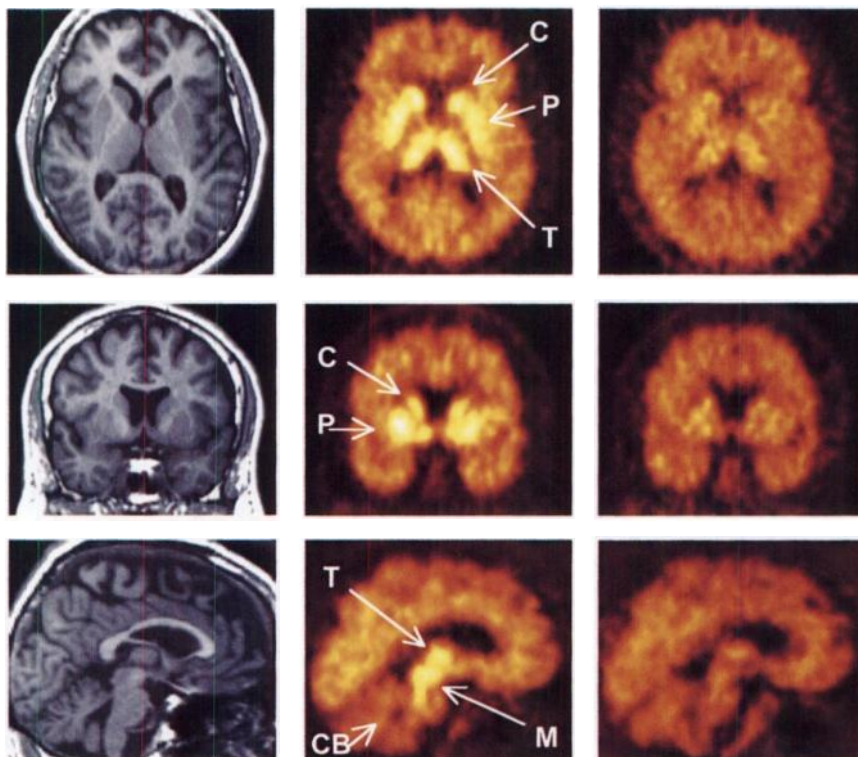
MR images (left column) and coregistered 10-min PET frames obtained from 70 to 80 min after injection of (+)-[¹¹C]McN 5652 (middle column) and (–)-[¹¹C]McN 5652 (right column). PET images are represented in a count-conservative manner, with same color scale and corrected for IDs. Transaxial (top row), coronal (middle row), and sagittal (bottom row) views are shown. At this time, increased activity concentrations in subcortical structures (C, caudate; P, putamen; T, thalamus; M, mid-brain) are easily detectable. Activity in cortex is only marginally higher than that in cerebellum (CB) on (+) images.
